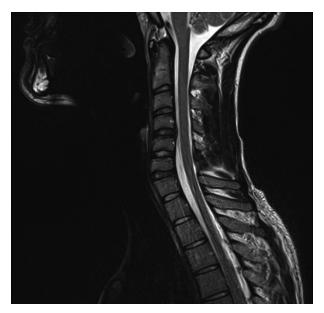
T2-weighted sagittal magnetic resonance imaging showing normally appearing discoligamentous structures, medulla, and cervical nerve roots.
